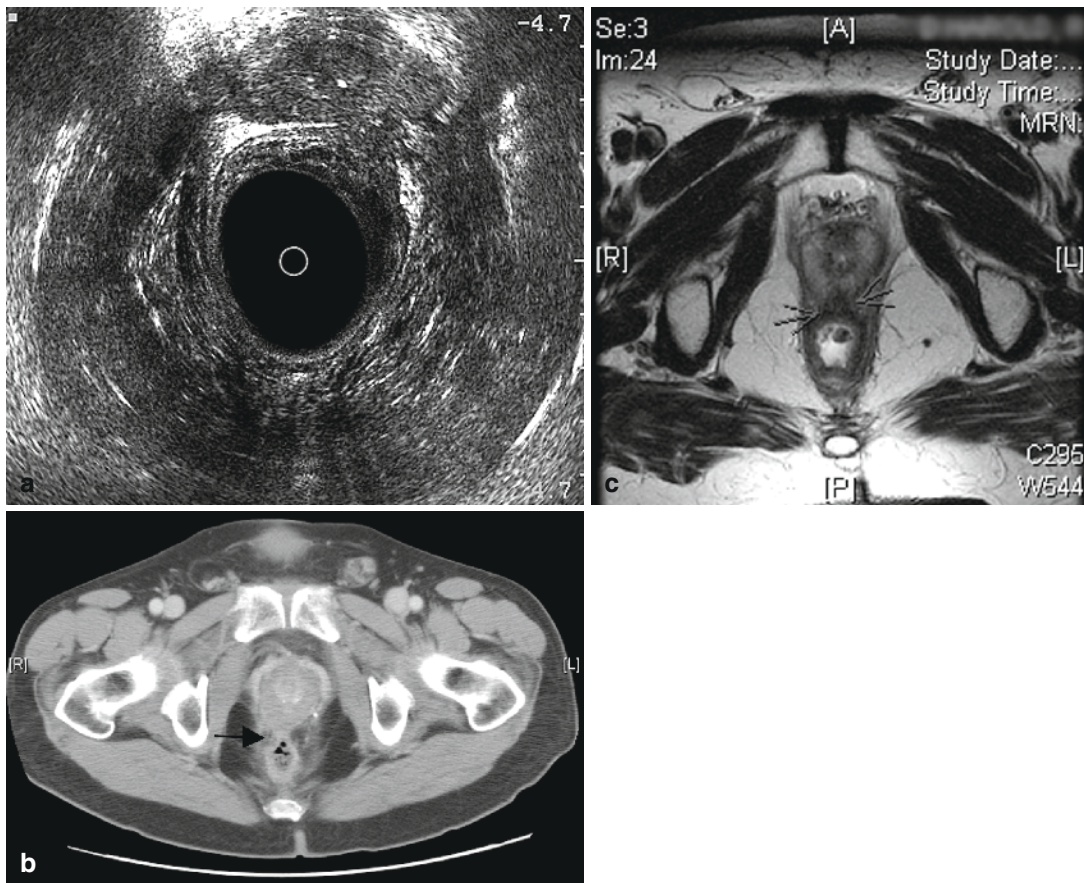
A comparison of EUS (a), CT (b), and MRI (c) in a patient who has rectal cancer with prostate invasion.
